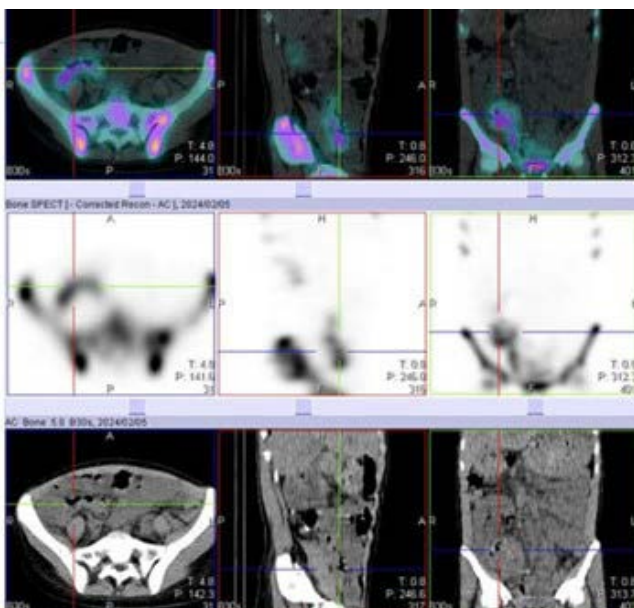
Four-hour SPECT/CT
